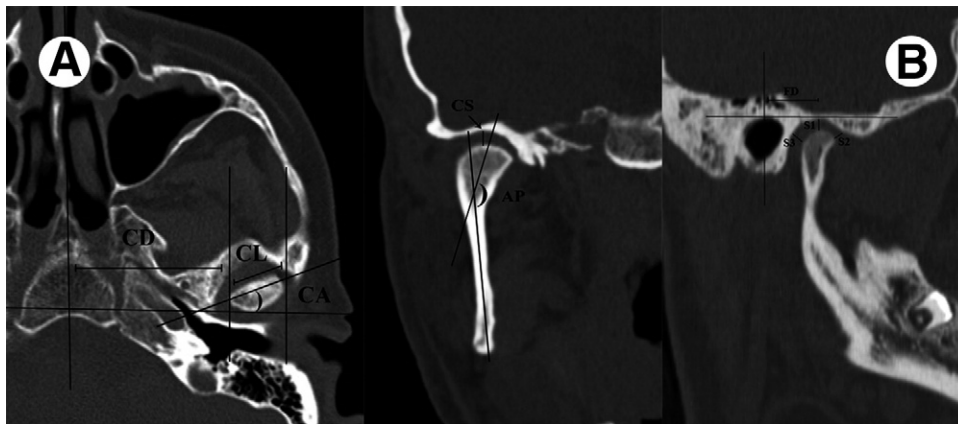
CT measurements made in transverse (A), in coronal (B), and sagittal view. CD: the condylar distance; CL: the condylar length; CA: the condylar angulation; CS: the superior coronal joint space; AP: the angulation of the proximal fragment; S1: the superior joint space; S2: the closest anterior joint space; S3: the closest posterior joint space (S3); FD: the fossa distance.
